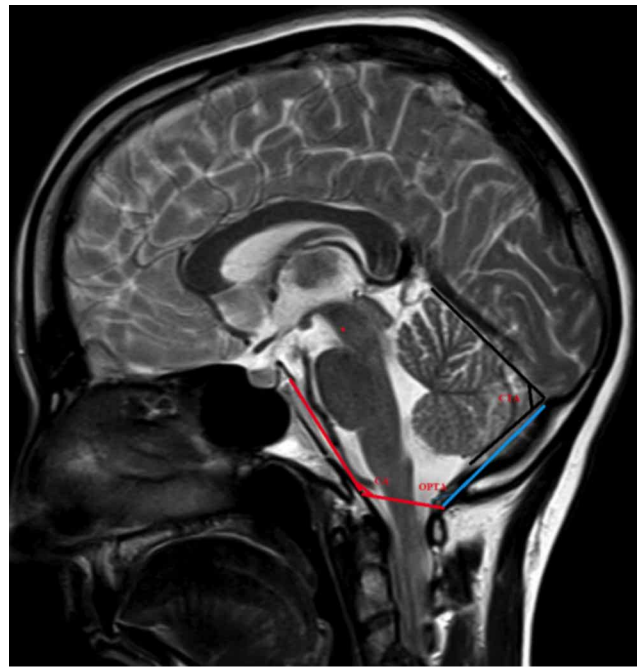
Posterior cranial fossa angle measurements. CA:Clival angle; OTA:Occipital protuberance angle; CTA:Cerebellar tentorium angle.
